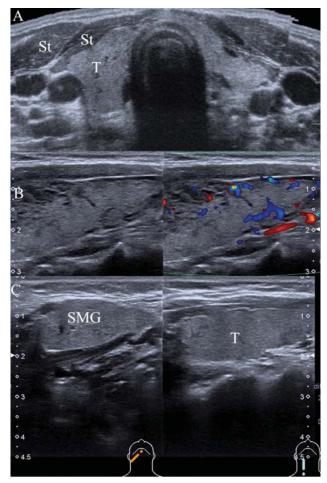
Normal thyroid. A; Panoramic ultrasound view showing thyroid (T) that is has a homogenous texture and is more echogenic than strap muscles (St). B; Normal vascularity of thyroid, note that the peripheral vascularity is slightly more than central vascularity. C; the normal thyroid (T) and submandibular gland (SMG), note how the two appear to have an almost identical texture.
